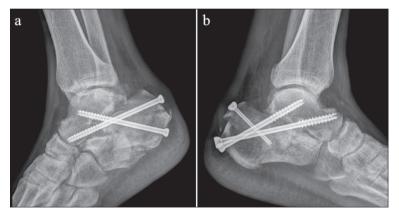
Immediate postoperative lateral X-rays; plain radiograph obtained immediately after surgery; a) right foot; b) left foot
